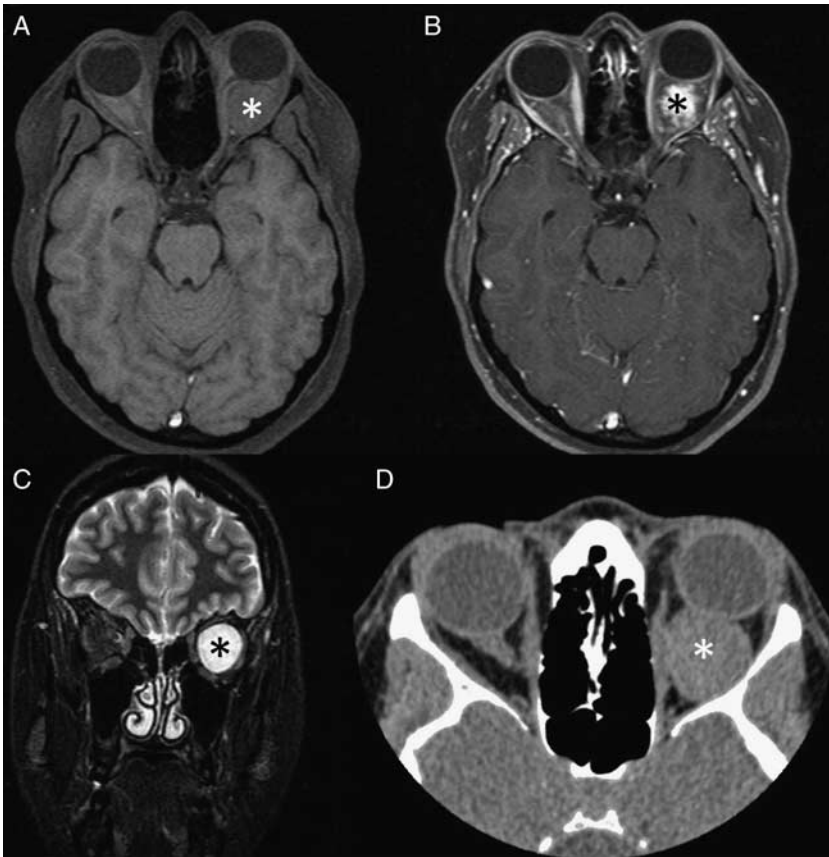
42-year-old woman with longstanding proptosis was found to have a retrobulbar mass with imaging features consistent with a cavernous hemangioma. The patient was asymptomatic and elected to forego any surgical intervention. Axial T1-weighted fat-saturated noncontrast MRI demonstrates a well-circumscribed T1 isointense mass in the left intraconal space (A, white asterisk). Axial T1-weight fat-saturated postcontrast MRI demonstrates heterogenous enhancement of the mass (B, black asterisk). Axial T2-weighted MRI demonstrates a T1 hyperintense mass in the left intraconal space (C, black asterisk). Axial noncontrast computed tomography demonstrates a high-attenuation mass in the intraconal space (D, white asterisk). MRI indicates magnetic resonance imaging.
